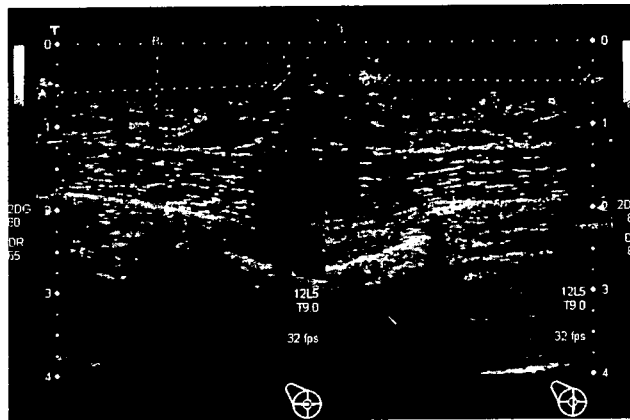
Ultrasonography of the bilateral breasts showed ill-defined, heterogenous, echo-poor areas of nodularity deep to the nipple
